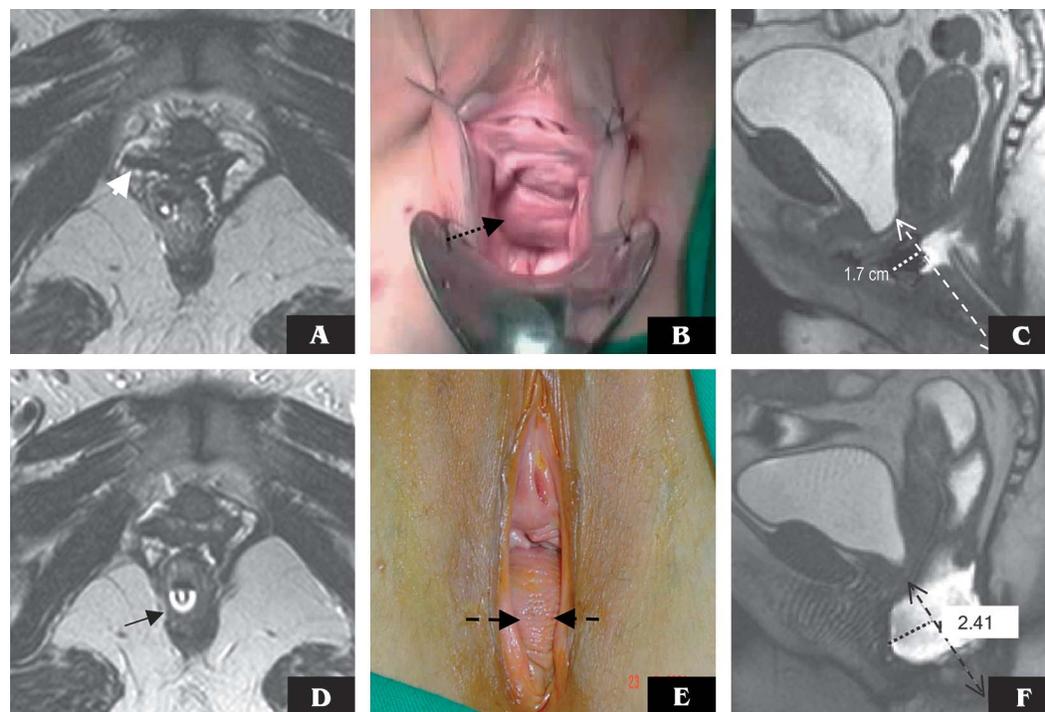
Images from a 51-year-old woman with postoperative recurrent stress urinary incontinence and de novo fecal incontinence with attacks of constipation. A, Preoperative axial T2-weighted TSE MR image (5000/132 [repetition time (ms)/echo time (ms)]) shows right paravaginal endopelvic fascial defect, evident by the loss of the H-shaped vagina on the right side (short arrow) perfectly correlating with the intraoperative findings in the photograph of the pelvic floor (B) (dashed arrow) with the patient in the lithotomy position (dashed arrow). C, Sagittal balanced fast field echo MR image during straining (5/1.6 [repetition time (ms)/echo time (ms)]) reveals urethral hypermobility, cystocele, uterine descent, and rectocele. D, Postoperative Axial T2-weighted TSE MR image (5000/132 [repetition time (ms)/echo time (ms)]) shows a persistent endopelvic fascial defect, and suspected external anal sphincter defect on the right side at 9 o'clock (arrow). E, F, Postoperative photograph of the pelvic floor with the patient in the lithotomy position (E) and sagittal balanced fast field echo MR image during straining (5/1.6 [repetition time (ms)/echo time (ms)]) (F), show marked exaggeration of the previous rectocele not included in the operation, which could explain the attacks of constipation (dashed arrows) (E); (calipers) (C and F).
